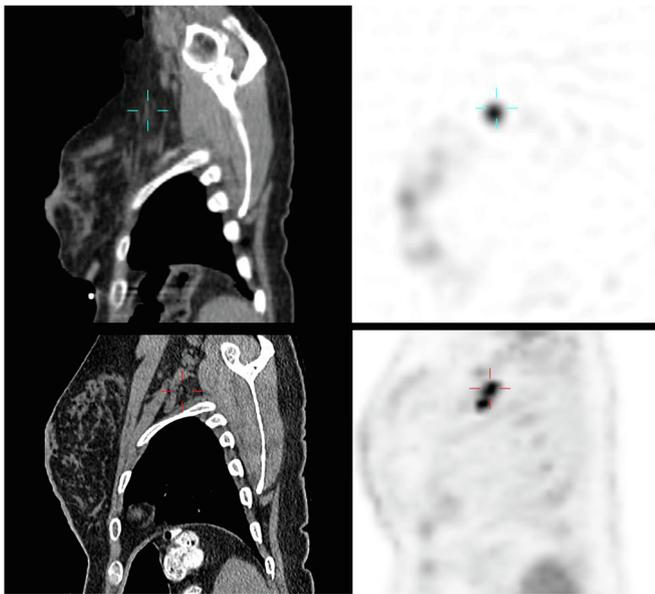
^{99m}Tc -Nanotop SPECT/CT (top) and FDG PET/CT (bottom) images of a patient with non-concordant positive lymph nodes visualized in the left axilla. b-sagittal.
